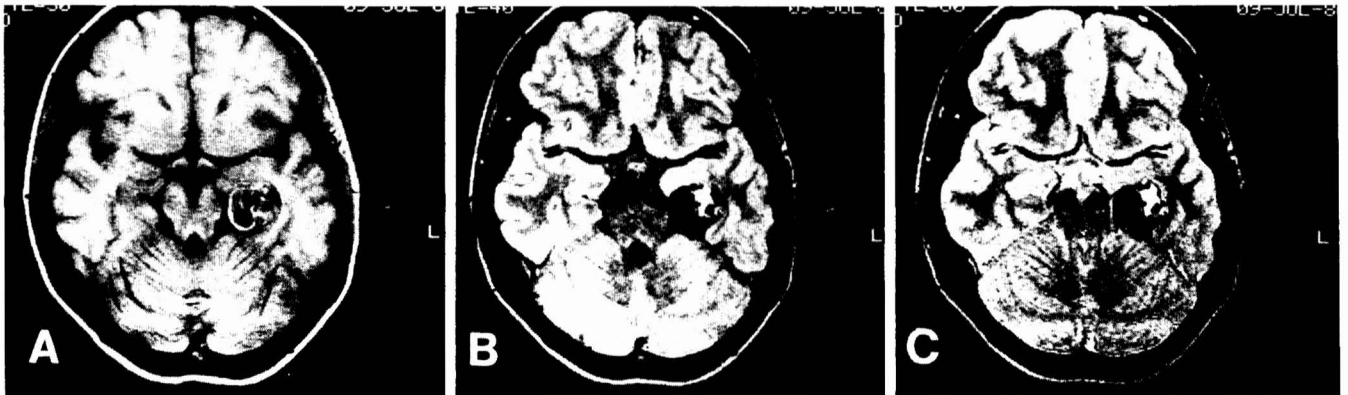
Case 1. A: T1-weighted image (TR 500 ms/TE 30 ms) showing central mixed signal intensity consistent with tissue matrix and chronic clot and rim of hyperintensity consistent with subacute blood (methemoglobin). B and C: T2-weighted images (TR 2000/TE 40,80) demonstrating progressive hypointensity in chronic clot (hemosiderin) and hyperintensity in tissue matrix.
